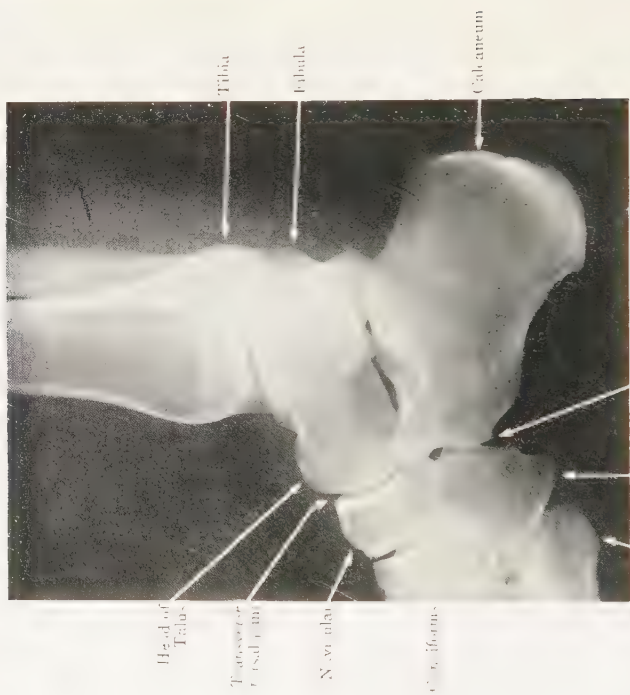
Lateral Radiograph of the same Ankle and Tarsus. (Dr. J. Duncan White.)
